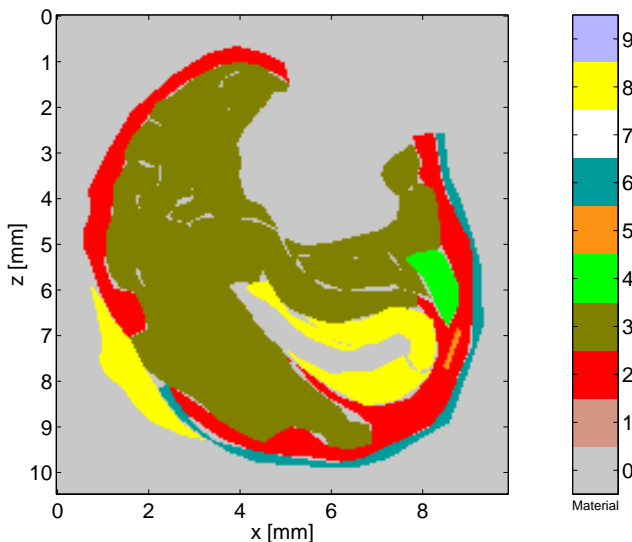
The reference map corresponding to the ultrasound image in Figure 3. The colors correspond to the definitions in Table 1. Note that material 7 is not used.
